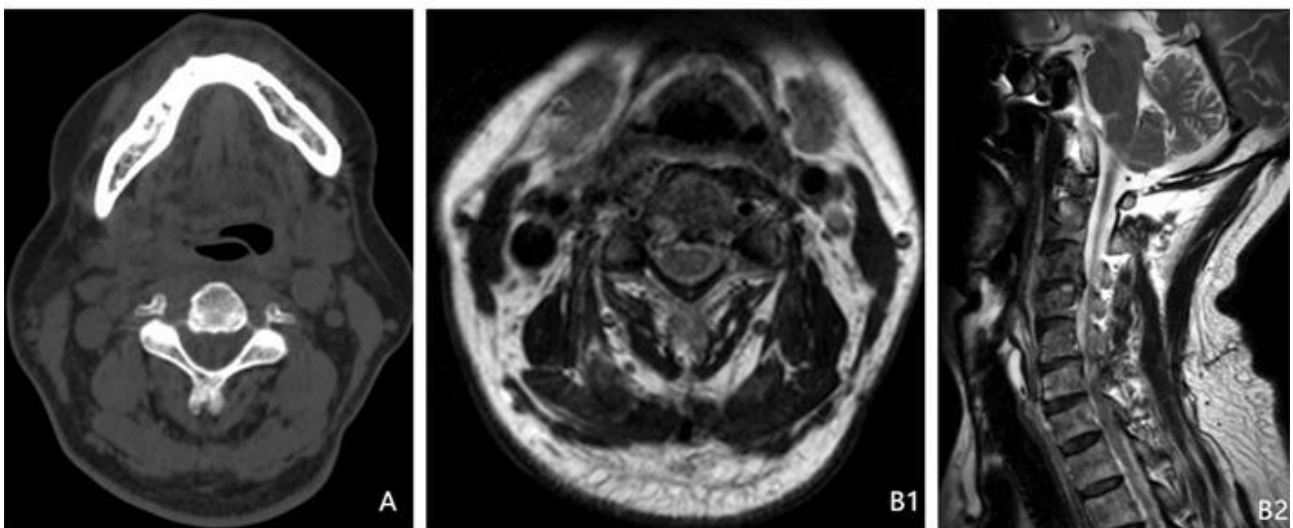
Postoperative CT Scan/MRI. (A): Axial CT images preservation of medial wall of intervertebral space foramina, wide intervertebral space, no compression or stenosis, adequate decompression. (B) (B.1 & B.2): T2W MRI show no compression on spinal cords.
